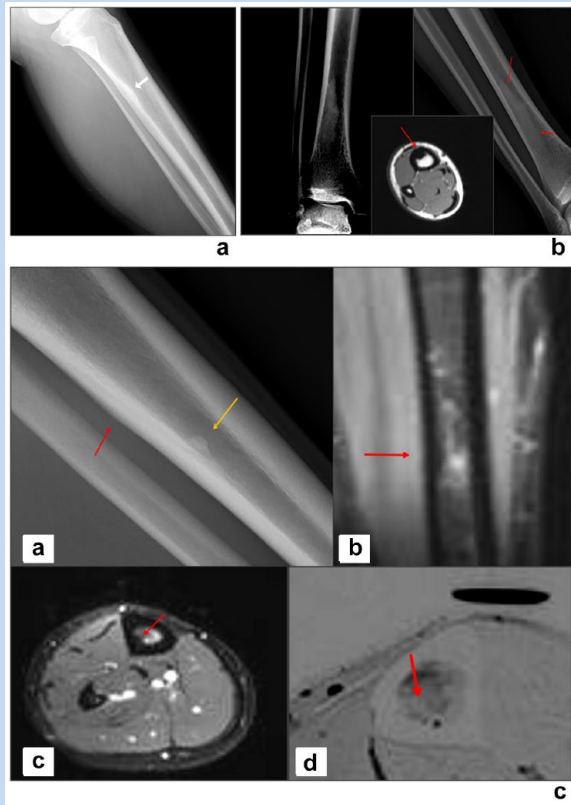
Examples of ENB (different patients). (a) Lateral radiograph with ENB. Arrow demarcates ENB formation at the left posteromedial proximal to midcortex. (b) STIR image. AP/lateral radiograph and axial MRI indicating endosteal sclerosis. (c, d) Axial views of lateral mid tibia with ENB; 3 had both evidence of PNB and ENB. A total of 27 tibia demonstrated that bony changes were seen on lateral radiographs, 17 were seen on AP; 7 tibias demonstrated findings on both AP and lateral views. Overall, 34 of 124 (27%) tibia showed evidence of PNB or ENB formation that coincided with evidence of BSI on MRI and noted location of pain on clinical examination. Four tibias demonstrated discordant PNB, which was not associated with a site of pain but was associated with patients who noted a previous BSI. The average thickness of PNB ranged from 1.5 mm to 5 mm (average, 2.5 mm) and all findings (27 of 146) on lateral view films were located on the posterior cortex. PNB was found in the proximal third of the tibia on 9 radiographs, in the middle third on 19, and in 6 on the distal tibia. Bone sclerosis was seen on 3 radiographs, of which 2 were seen in the distal third of the tibia. A nonossifying fibroma was found on 4 of 160 (2.5%) of tibias imaged. Using evidence of PNB or ENB on radiograph yielded a sensitivity of 27%, specificity of 100%, PPV of 100%, and NPV of 17%. AP, anterior posterior; BSI, bony stress injury; ENB, endosteal new bone; MRI, magnetic resonance imaging; NPV, negative predictive value; PNB, periosteal new bone; PPV, positive predictive value; STIR, short TI inversion recovery.
